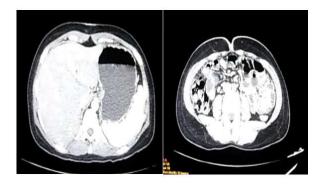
CT images showing hyperenhancement of the hepatic capsule with minimal perihepatic fluid and mild fluid in POD and pelvic cavity
